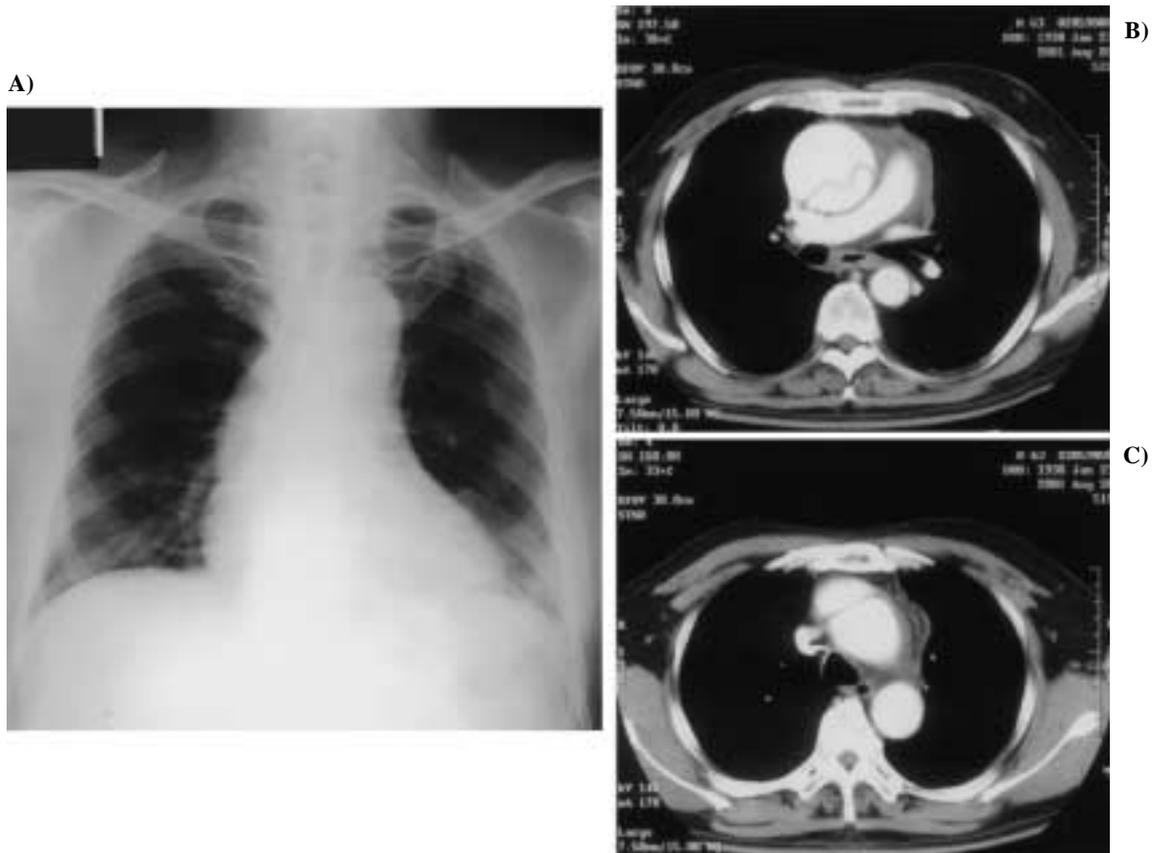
A chest roentgenogram revealed a widened mediastinum (A), and CT demonstrated an aortic dissection of the ascending aorta (B) without dissection of arch (C).
